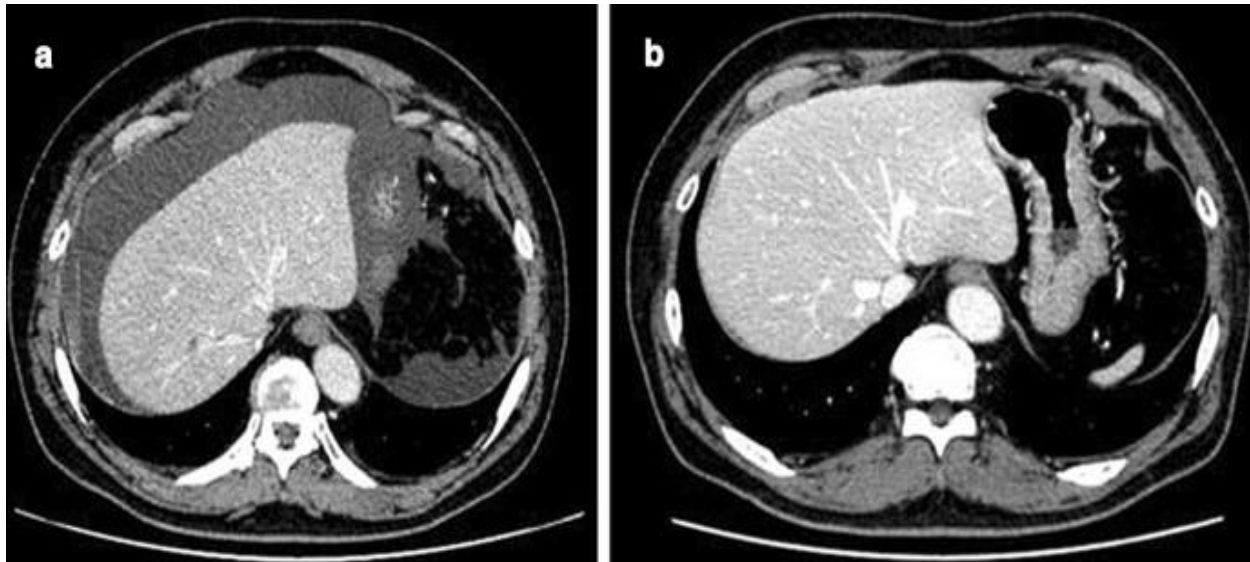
Two examples of colon CT scan images (tumor areas with bright spots)
